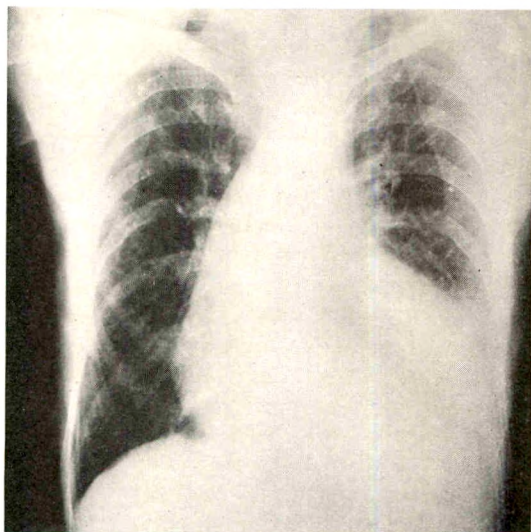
Case 1. Roentgenogram of the chest taken in the posteroanterior position. Note the absence of the aortic knob, the presence of a left ventricular hypertrophy, the prominence of the ascending aorta and the erosion of the ribs.
